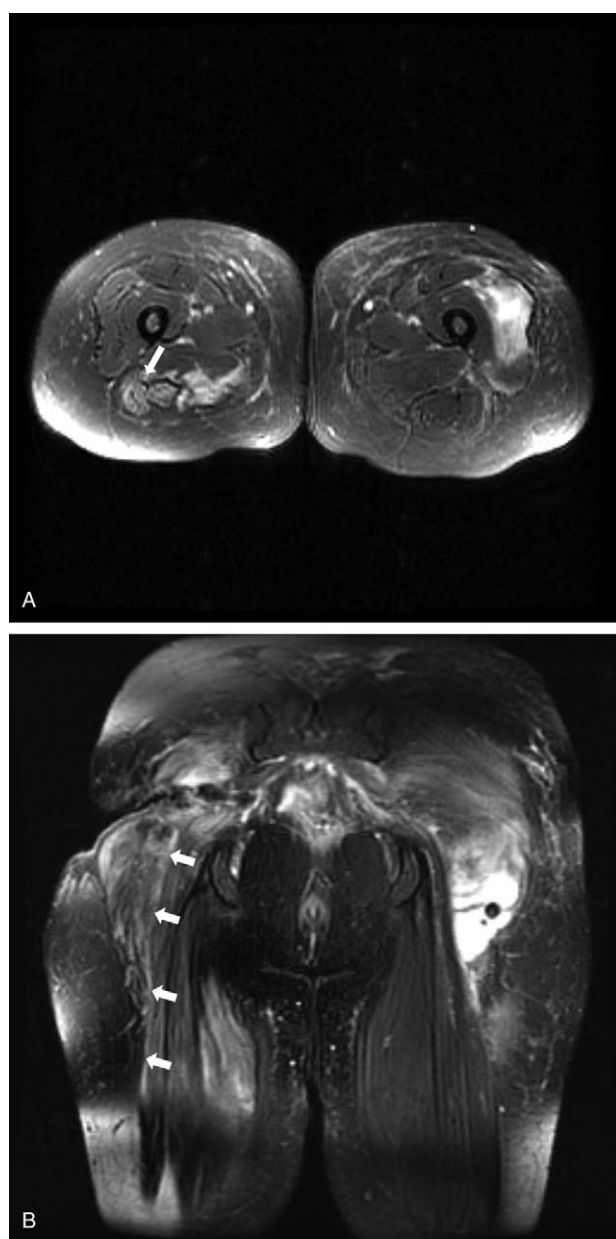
Axial T2-weighted fat suppression (A) and coronal T2-weighted fat suppression (B). Magnetic resonance images reveal edematous changes with a reticular pattern or inflammatory soft-tissue swelling around the sciatic nerve (arrows) from the level of the right sciatic notch to the level of the right subtrochanteric femoral neck. The left sciatic nerve appears to be normal.
